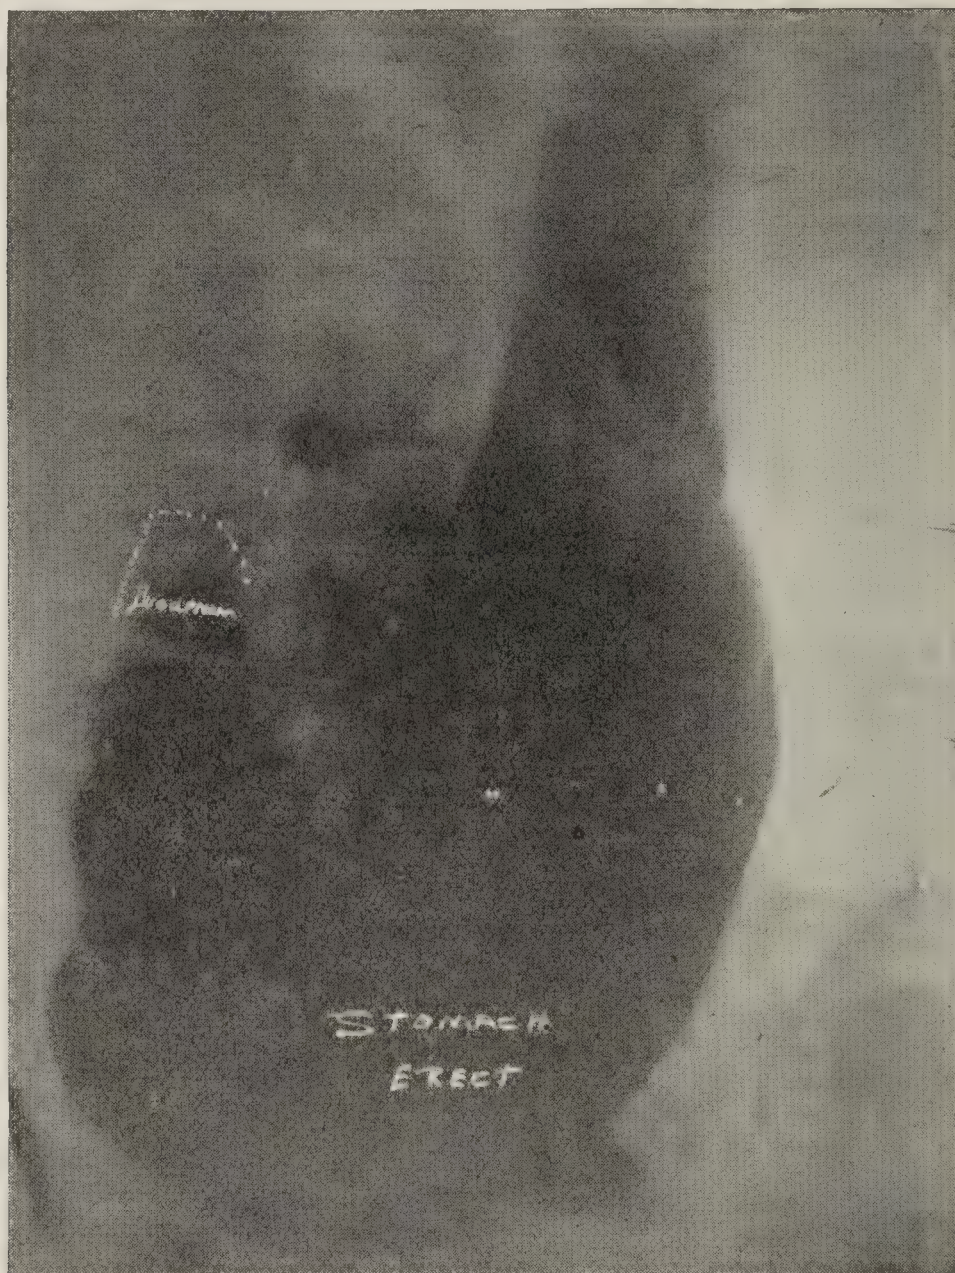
X-RAY FINDINGS OF THE STOMACH.
